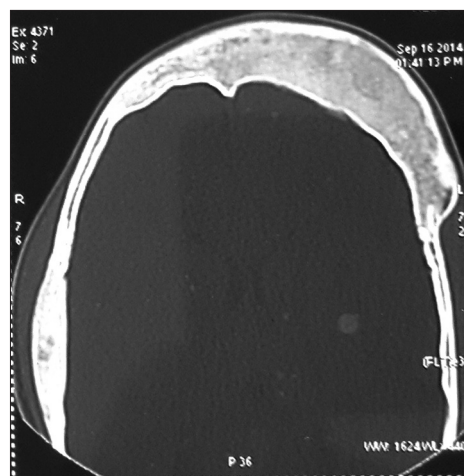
Axial computed tomography image shows expansion of left frontal bone
